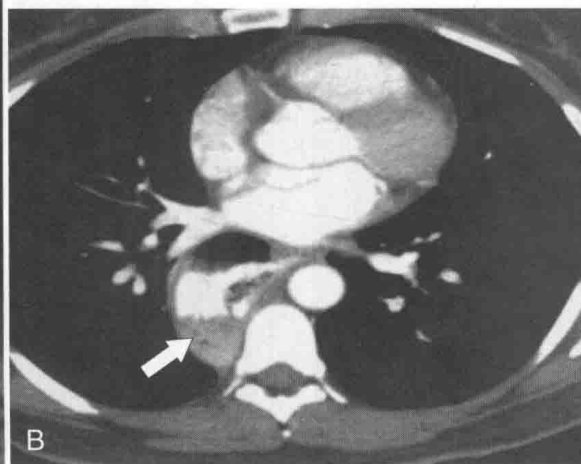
Coronal (A) and axial (B) contrast-enhanced CT in a 66-year-old man with a midesophageal pulsion diverticulum (*arrow*). Contrast freely refluxes through the wide-necked orifice (*arrow*).
